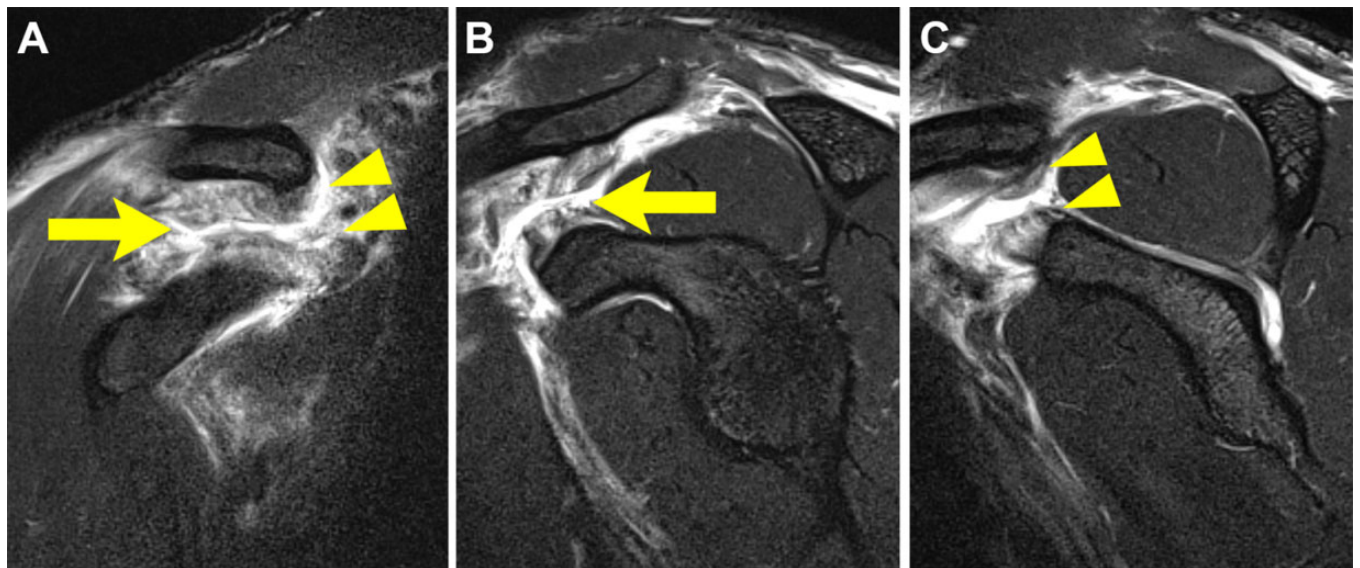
Grade 3 acromioclavicular injury: complete tearing of coracoclavicular ligaments. (A) Coronal T2-weighted fat suppressed and (B, C) sagittal T2-weighted magnetic resonance imaging scans show acute tearing and disruption of the trapezoid (arrows) and conoid (arrowheads) ligaments.
